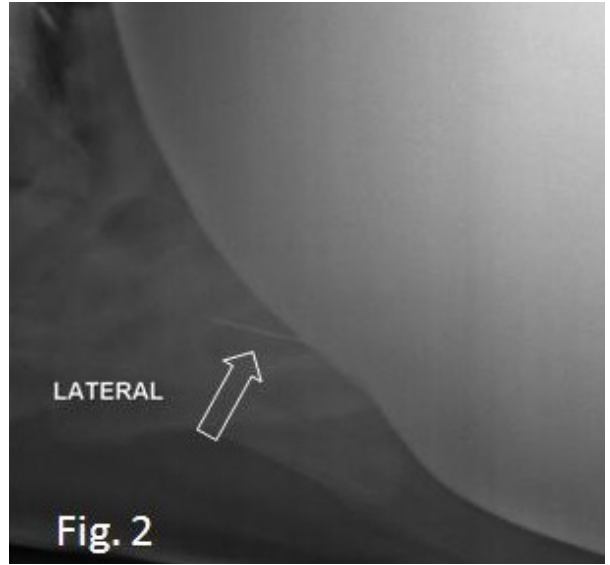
Contrast radiograph demonstrating extra-reticular sharp metallic foreign body opacity (white arrow).
